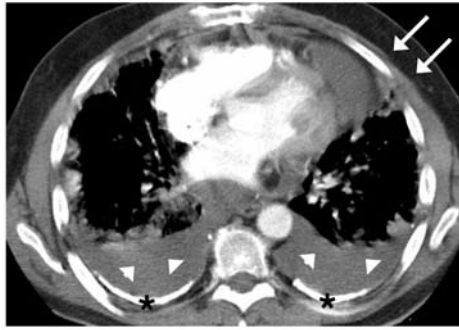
Axial CT scan of the chest showing prominent pericardial effusion (arrows). Calcified pleural plaques (asterisks) and pleural effusion (arrowheads) are also evident.
